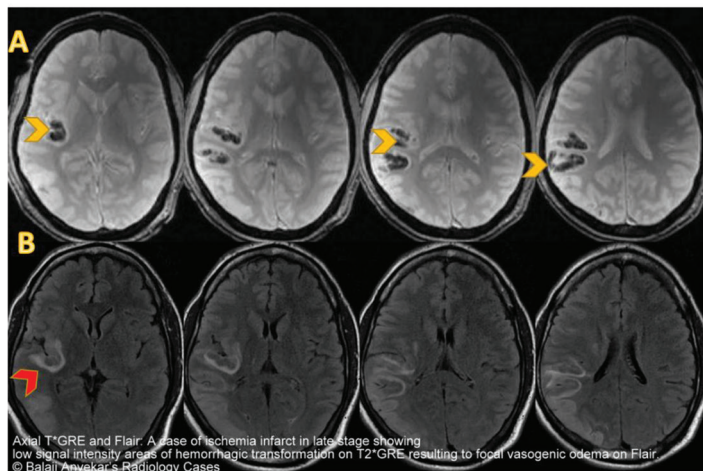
Hemorrhagic transformation. Hemorrhagic transformation of an ischemic infarct evident on MRI. A: T2 GRE showing areas of hypointensity (yellow arrowheads) corresponding to hemorrhage. B: FLAIR sequence showing the edema associated with bleed (red arrowhead).
